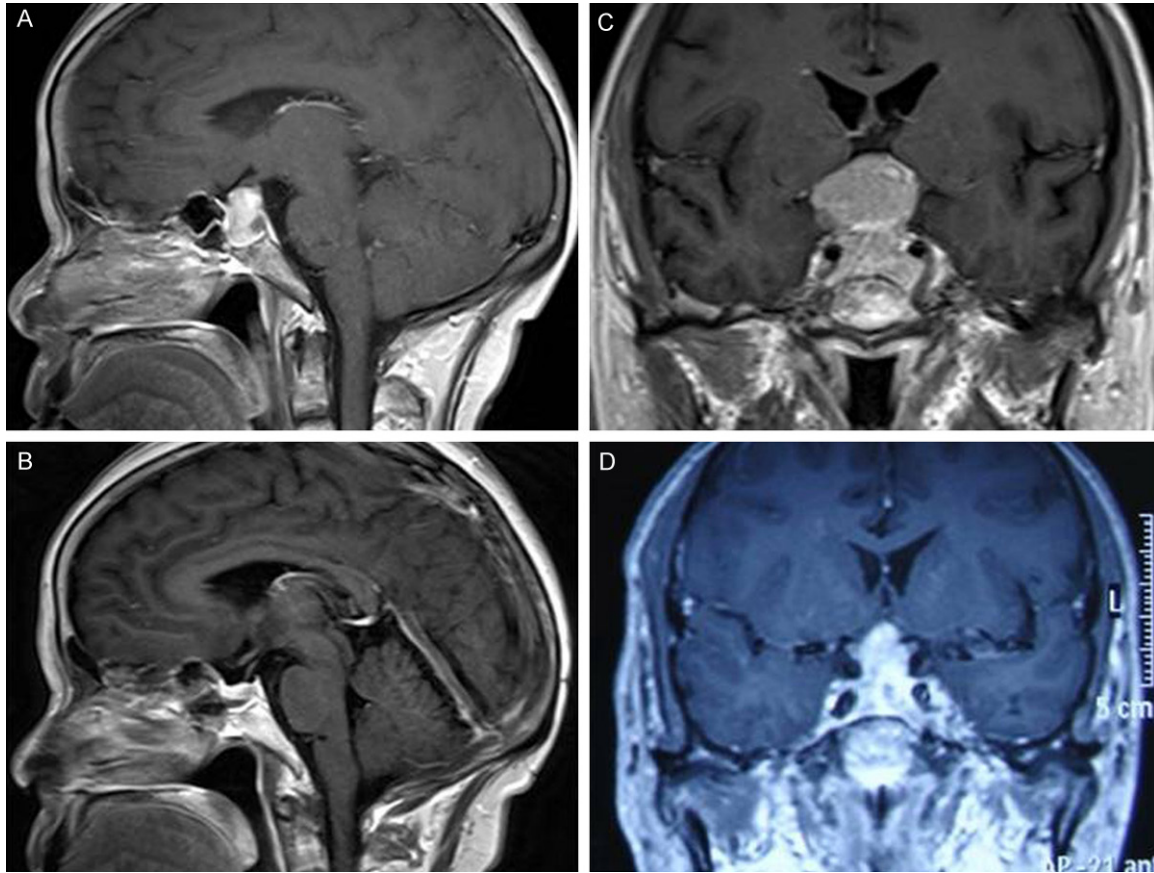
Pre- and post-operative MRI scans. A. The sagittal-T1-weighted enhanced image displays a tumor of the sellar region that invaded into the suprasellar region. B. Enhanced MRI scan was performed after radiotherapy, revealing the regression of the tumor, the pituitary stalk and optic chiasm. C. A coronal-T1-weighted enhanced image presenting a tumor located within the sella and the suprasellar region is shown. D. Enhanced MRI scan after radiotherapy showing substantial tumor regression.
